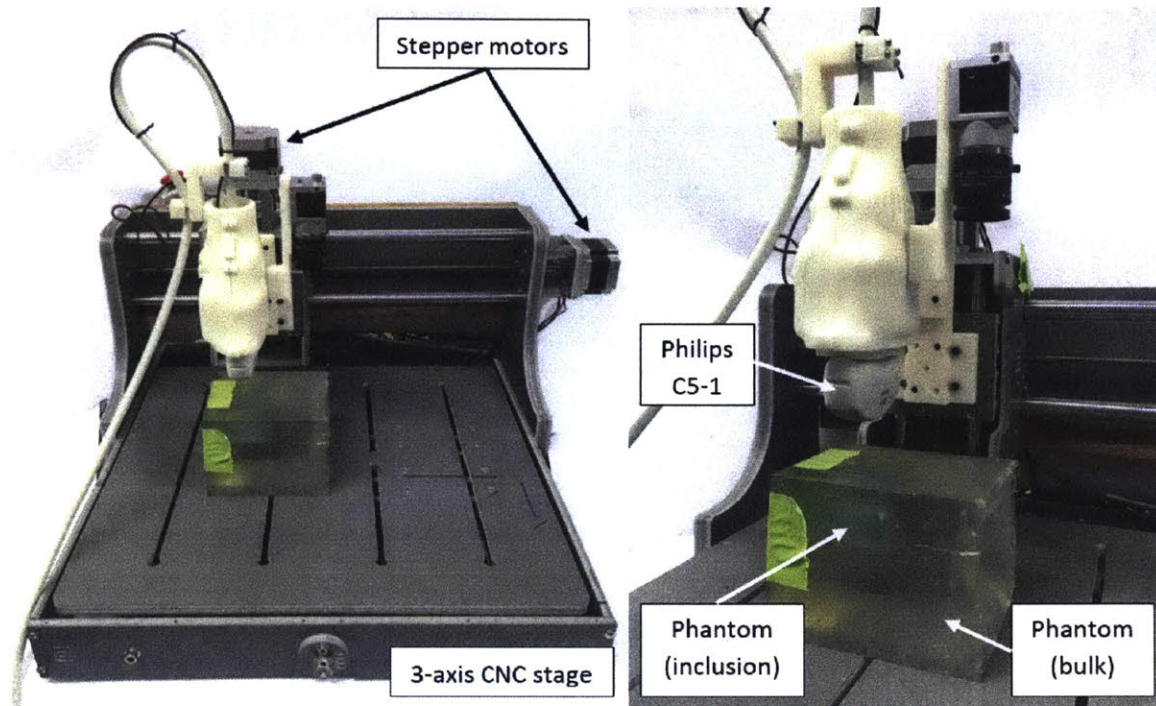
CNC stage with custom probe mount for the acquisition of linear ultrasound sweeps with controlled preload
